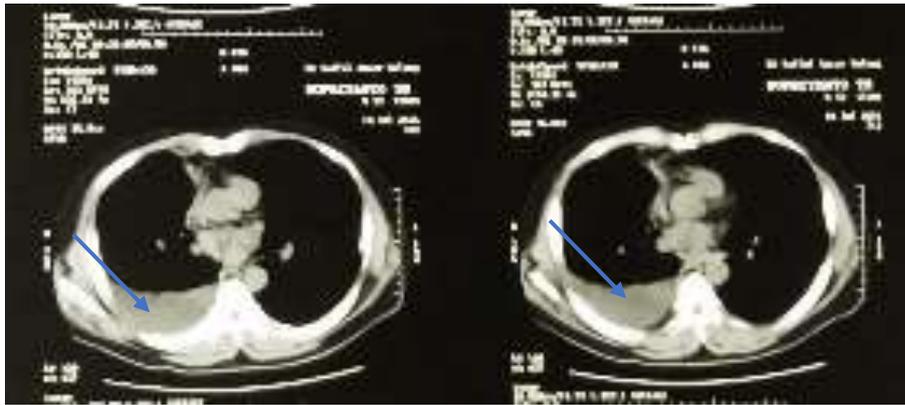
Thoracic CT scan in July 2016 (the orange line shown tumor mass; the blue line shown the pleural effusion)
